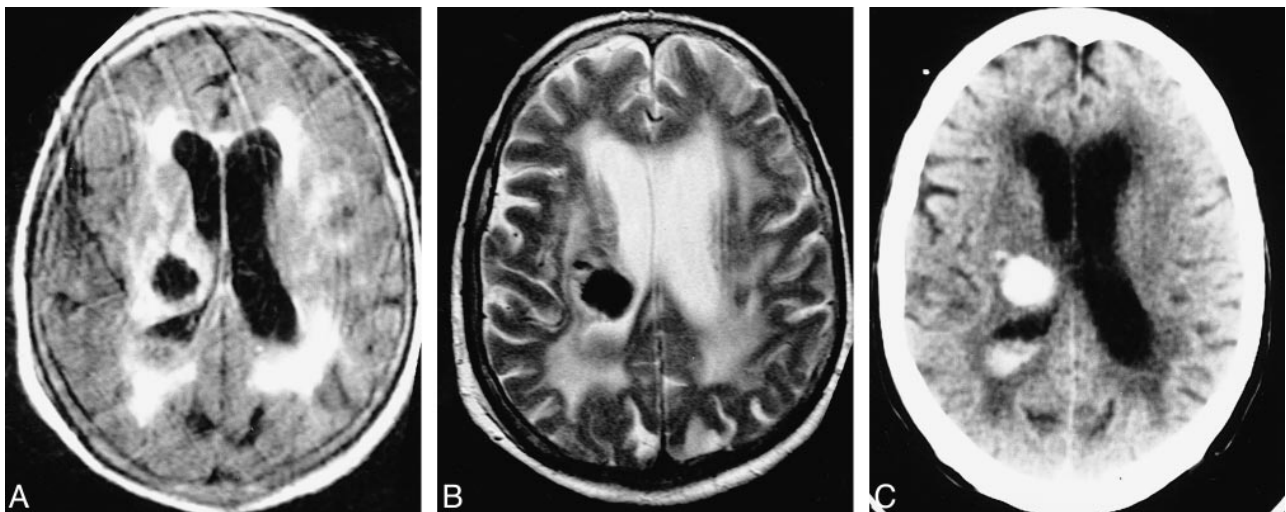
Case 9: 82-year-old woman with subacute IVH and intraparenchymal hemorrhage who had imaging 5 days after ictus. MR images and a CT scan were obtained 2 hours apart. The CT scan shows the IVH better than the MR images do.
